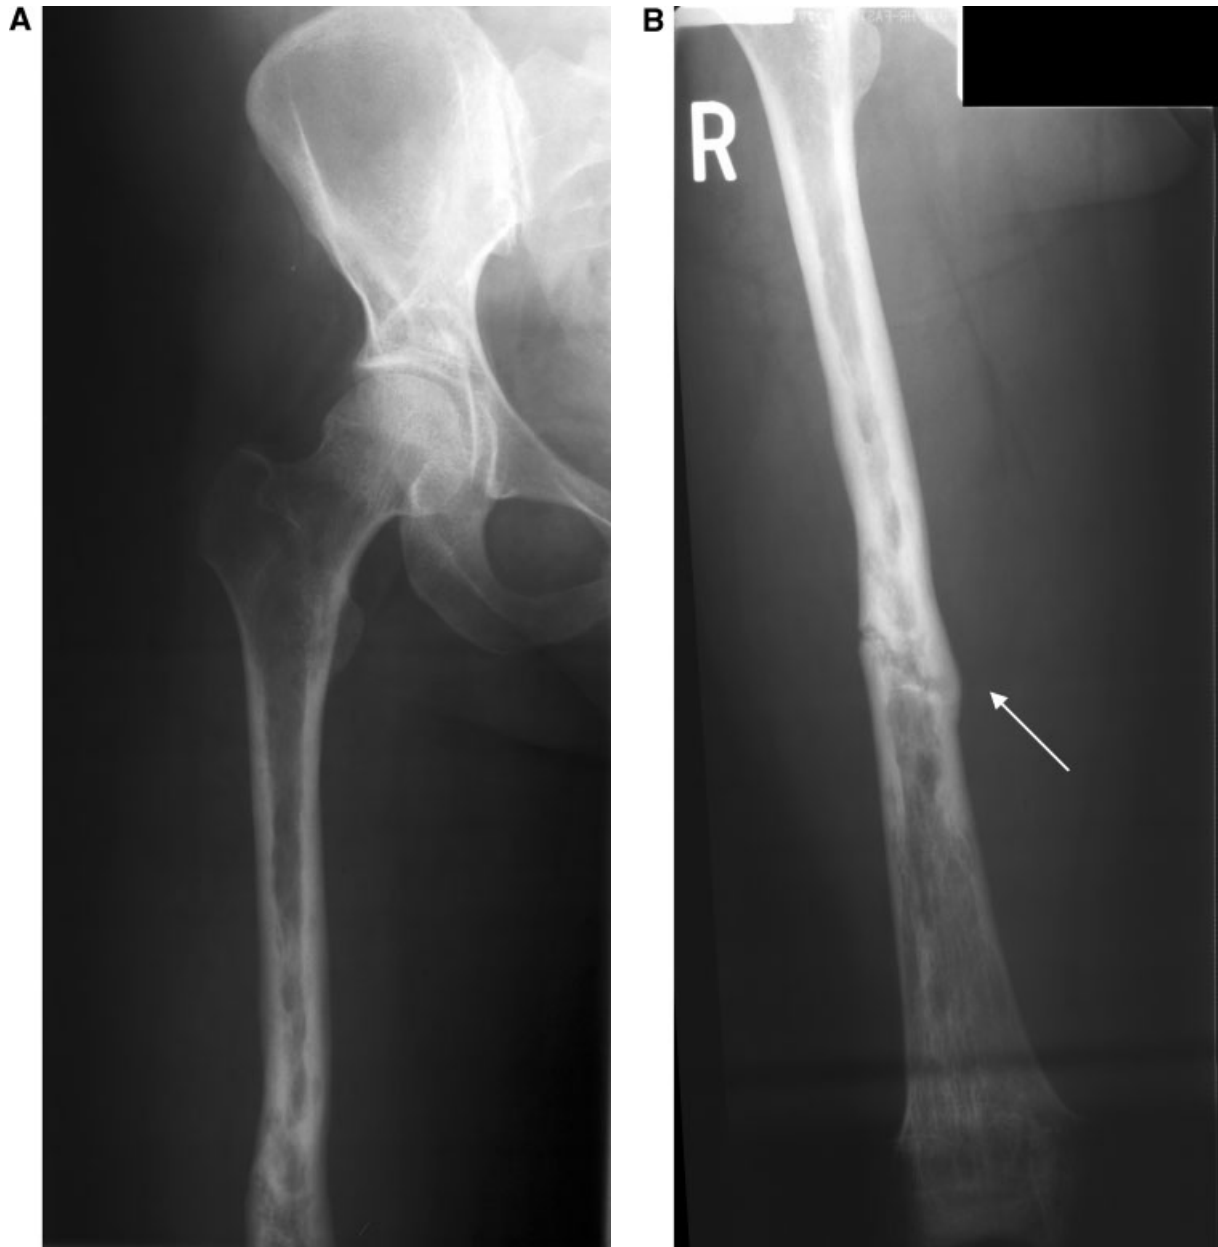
A: Radiograph of the right hemipelvis and femur of individual V-4 at age 36 y. shows coarse sclerotic trabeculation with increased cortical thickening of the femur. The medullary cavity is narrowed. B: Roentgenogram of the right femur in individual V-4 shows patchy sclerosis and radiolucent and osteopenic bones. The arrow indicates an old fracture that has not completely healed with only some normal callus formation.
